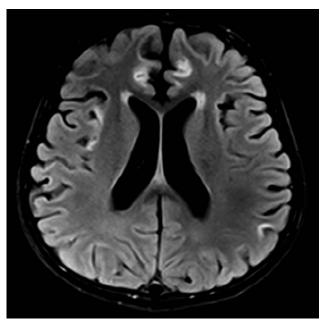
Axial flair MRI showing bilateral hyperintense subcortical frontal lobes, peri frontal horns, and mini subcortical lesions in temporal lobes with mild-moderate enlarged lateral ventricles.
